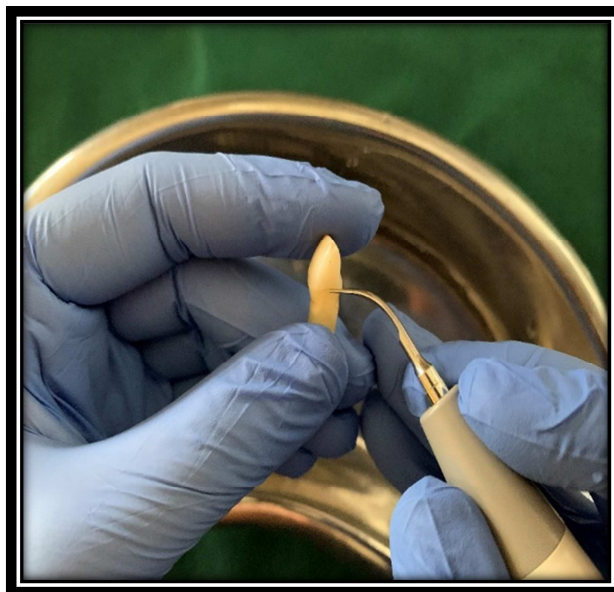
Removal of debris and calculus using ultrasonic scaler
